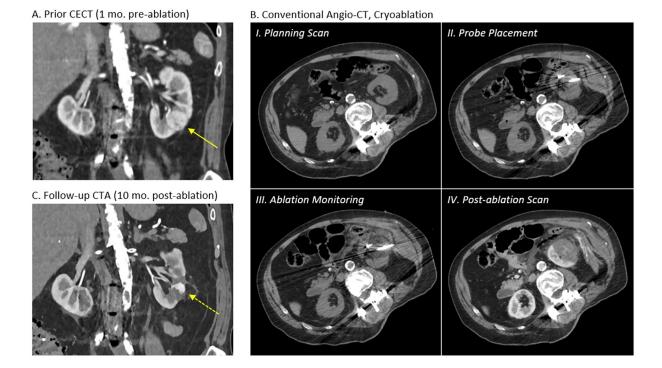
Cryoablation with conventional CT guidance. (A) Corticomedullary phase contrast-enhanced CT (CECT) obtained before initial treatment shows enhancing tumor mass (solid arrow). (B) Cryoablation phases include planning, probe placement, ablation monitoring, and post-ablation scan. (C) Coronally reconstructed image from CT angiogram (CTA) obtained 11 months following ablation shows intensely enhancing nodule centrally in the ablation zone (arrow), shown to represent vascular tumor at subsequent conventional angiography.
